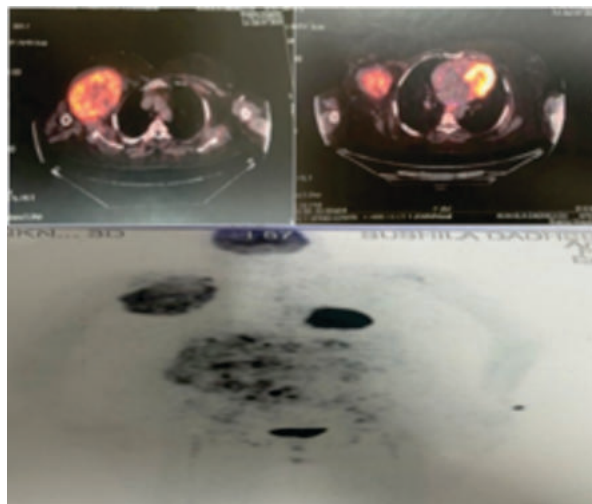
Whole-body PET-CT: Showed a Hypermetabolic Lobulated Mass in the Right Shoulder with Internal Necrosis and Calcification
